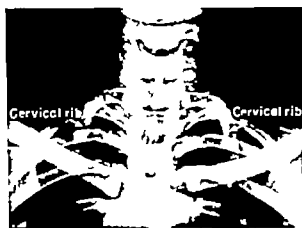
Roentgenographic demonstration of bilateral cervical ribs.
